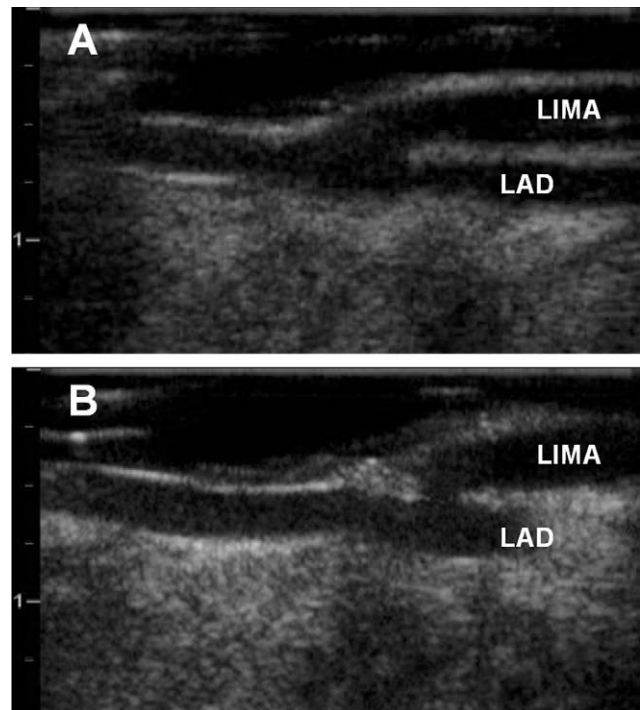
B-mode ultrasound images of the same LIMA–LAD anastomosis. (A) Fully patent anastomosis. (B) Stenotic anastomosis after placement of a deep stitch at the toe.
